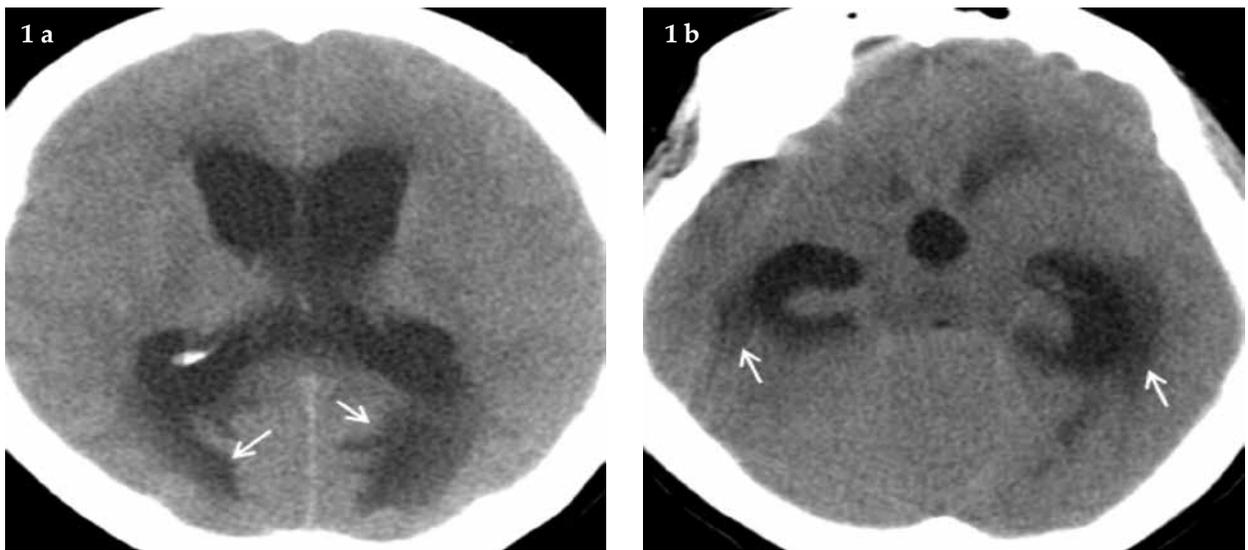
a, b) Head CT scan performed at the day of admission and showed howing moderate triventricular hydrocephalus and periventricular hypodensities suggesting transependymal CSF leakage (a,b, arrows). Note the effacemat of sulci, cerebral fissures and basal cisterns. The compressed brain stem is recognizable.
